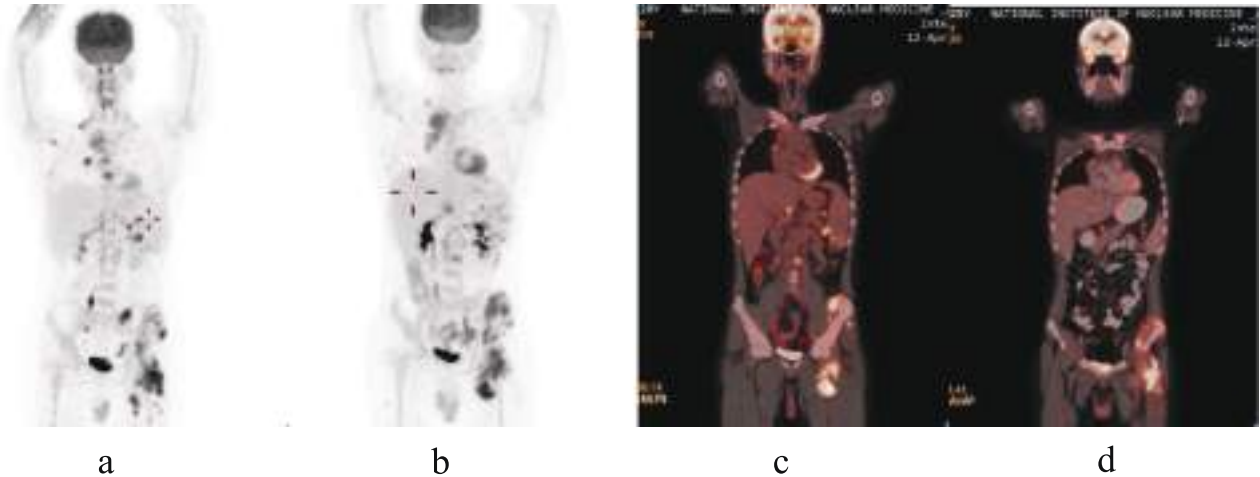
a, b ^{18}F -FDG PET MIP images & c, d whole body coronal PET-CT fusion images before and after chemotherapy showing persistent hypermetabolic muscular lesions and lymph nodes.
